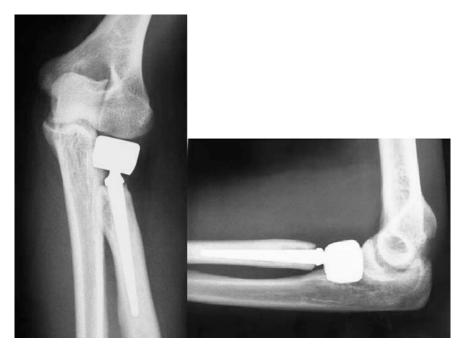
Radiographic follow-up after cemented bipolar radial head replacement
